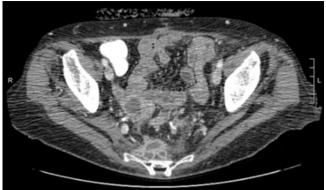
Pelvic abscess and colovaginal fistula: CT image of a patient who underwent sigmoid colectomy for diverticulitis complicated by anastomotic leak. The leak caused pelvic abscesses that necessitated through the vaginal cuff, thus resulting in a colovaginal fistula
